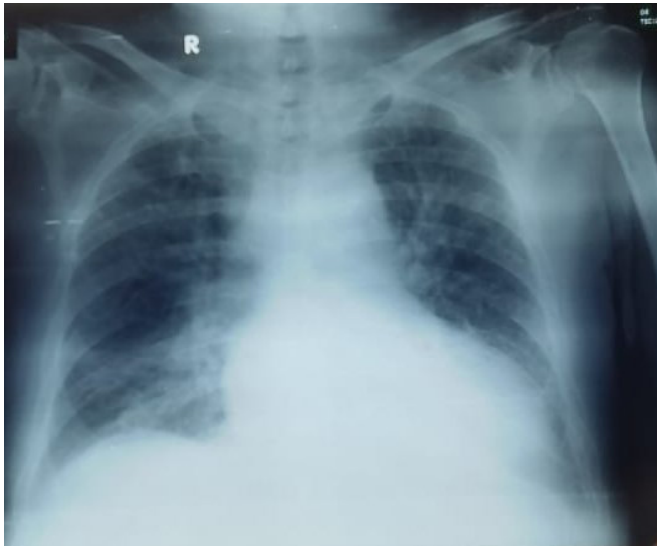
Chest X-Ray (CXR) started improving.
